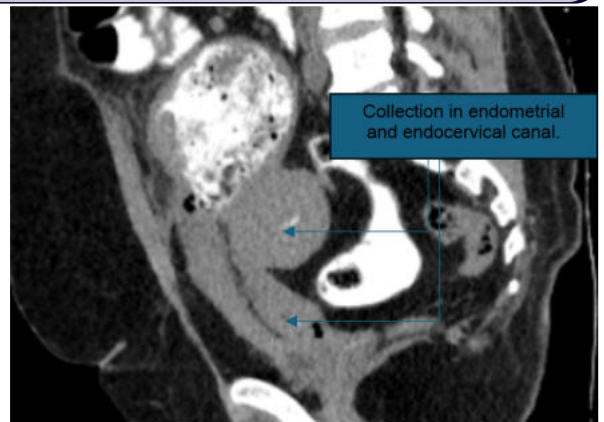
CT with oral contrast: Contrast opacification of the collection with extension into the uterine cavity confirming enterouterine fistula.
